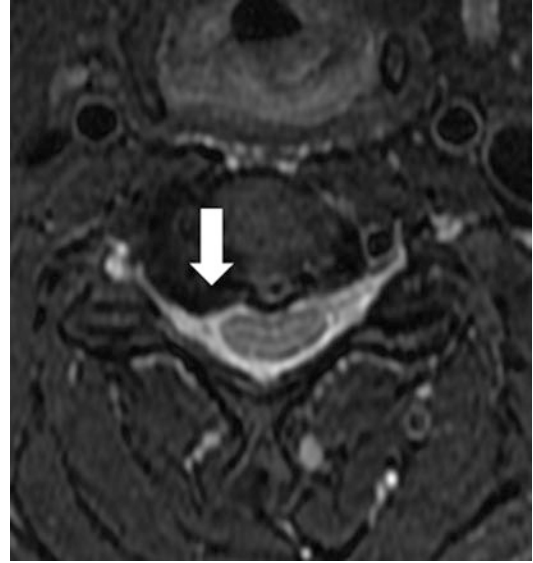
MRI demonstrating a chronic disc-osteophyte complex (*arrow*) causing nerve root compression. The decreased T2 signal within the disc protrusion suggests a chronic process with likely possible osteophyte formation
